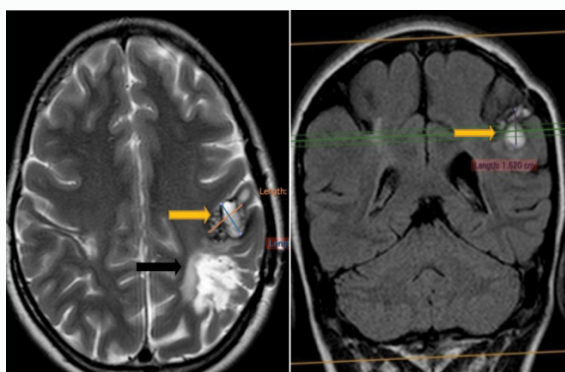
Two dimension view of contrast enhanced Preoperative MRI scan of a 20 years old female, showing cavernous malformations, she presented with epileptic seizures and headache, yellow arrow pointing the lesion on the left parietal region, EEG confirmed it symptomatic, Zabramski type 1. The black arrow is showing changes of cavernous malformation previously treated by radiosurgery.
